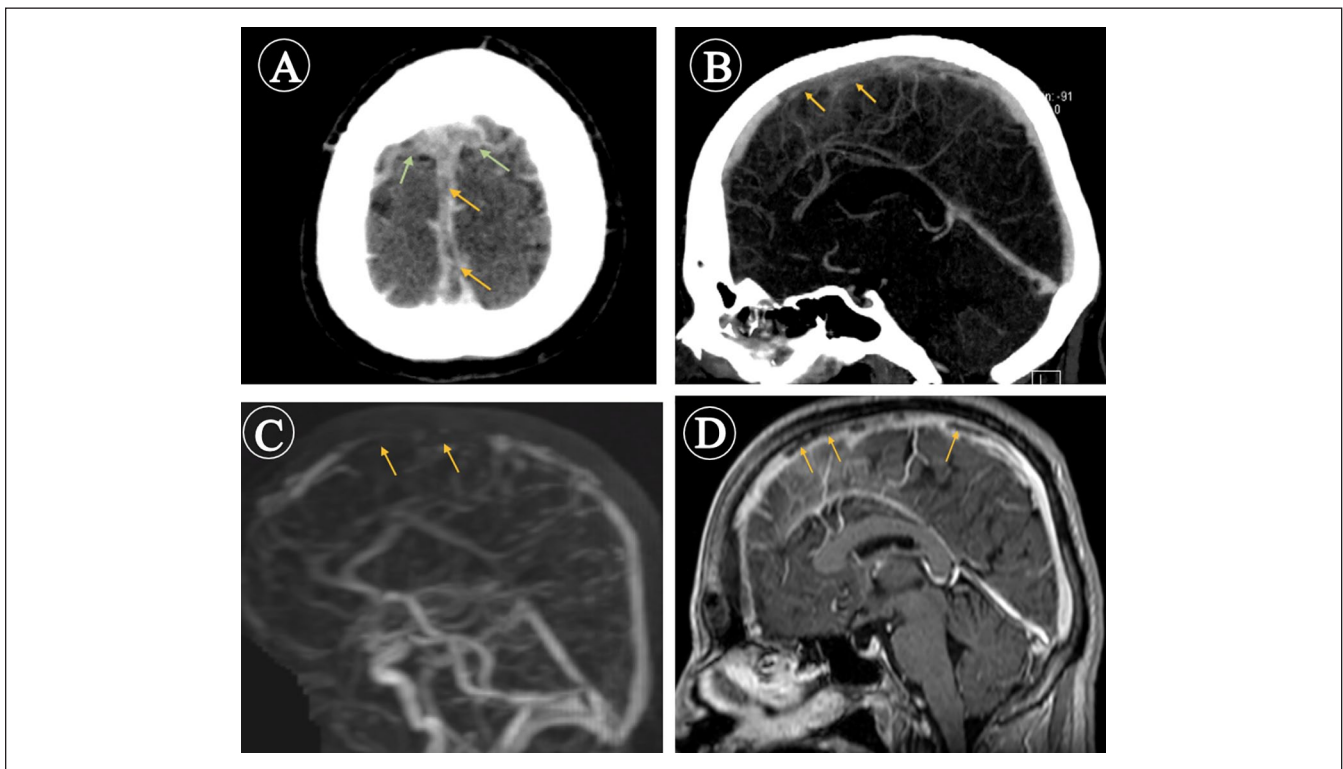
Computed tomography (CT) and magnetic resonance (MR) venogram scans. CT venogram axial (A) and sagittal (B) planes showing nonopacification of the anterosuperior aspect of the superior sagittal sinus (orange arrows) and adjacent cortical veins (green arrows) confirming their thrombosis. MR venogram (C) and MR sagittal (D) T1W-Fat sat postcontrast demonstrate filling defects within the anterosuperior aspect of the superior sagittal sinus (orange arrows).
